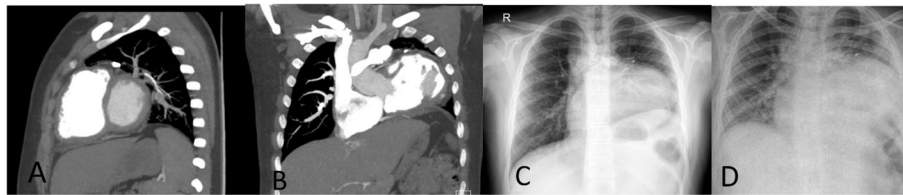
A, B CT scan of a 13-year-old patient who underwent complete correction of VSD PA atresia at the age of 1 year before diaphragm plication. C Chest film of the same patient. D Chest film of the patient after plication
